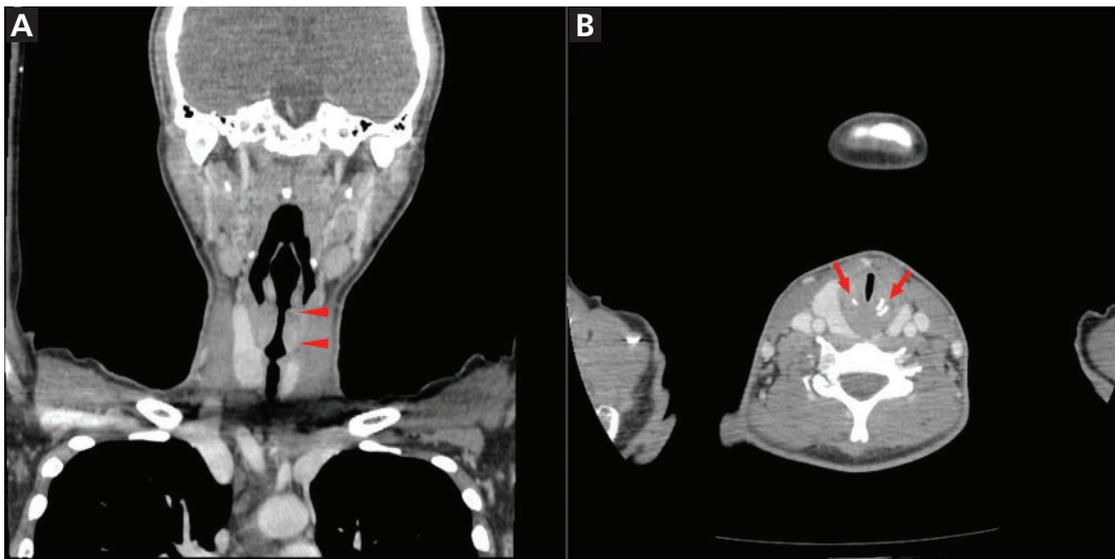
Computed tomography coronal (A) and axial (B) views of the head and neck showed severe subglottic stenosis (arrowheads), from which stenosis extended 2 cm in length, and tracheal calcification with sparing of the membranous posterior portion of trachea (arrows).
